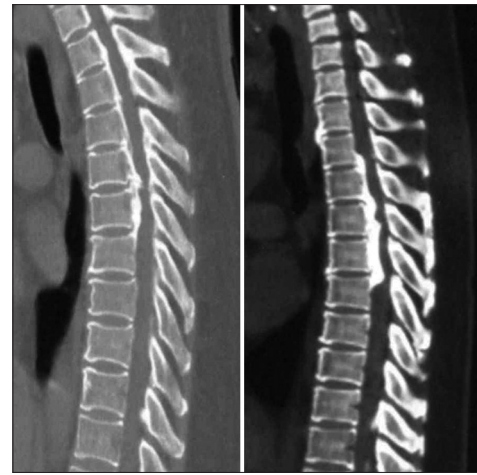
Computed tomography scan showing ossified posterior longitudinal ligament of dorsal spine
